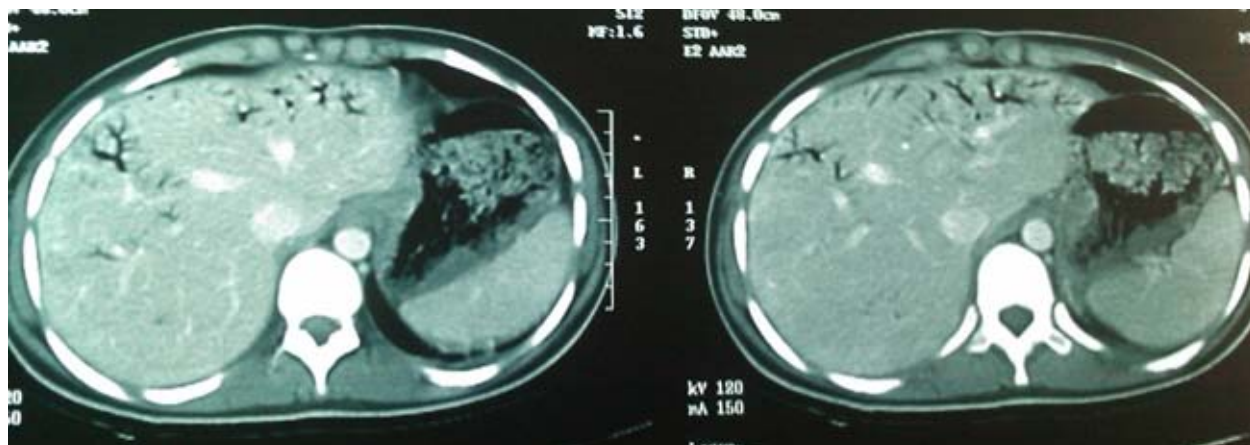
Intravenous enhanced emergency CT scan of the upper abdomen.
